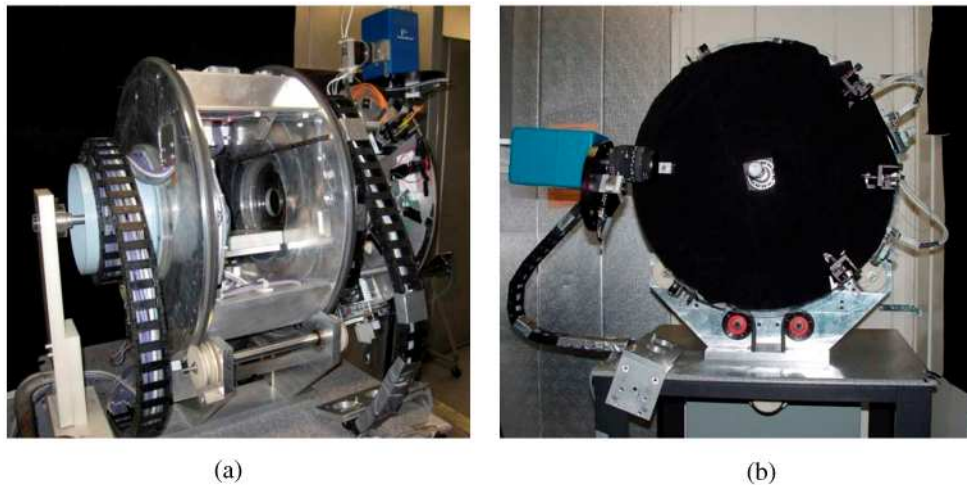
(a) The picture of the system from the side view showing the XCT counterpart. The x-ray source (top) and the flat panel detector (bottom) are positioned on a rotating gantry. All the electrical connections transferred to the gantry using wire harness belts. (b) The picture of the system from the front view showing the FT/DOT components.
